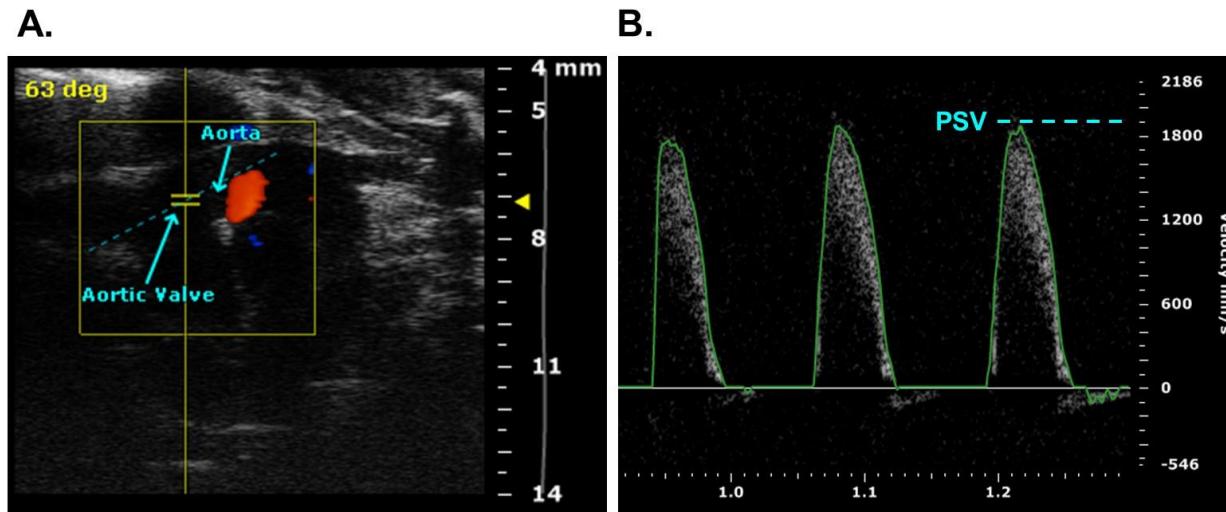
Sample Doppler ultrasound scan
